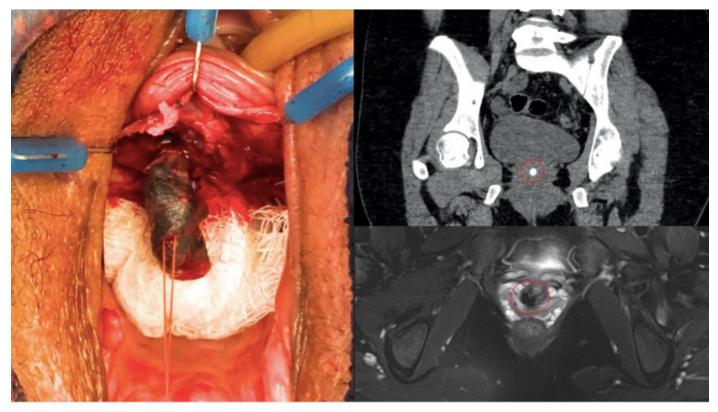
Periurethral lesion read on computerized tomography and MRI as possible calculus containing urethral diverticulum. On MRI calculi appear dark (low signal intensity) on T2-weighted images. Intraoperative findings confirmed lesion to be pyrolytic carbon periurethral bulking agent.
